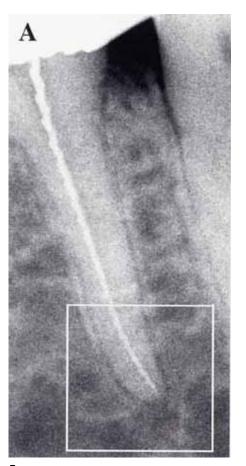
Image resolution is important for viewing fine detail. This is a portion of a conventional radiograph. The apical region (in white box) is shown in Figures 6b-d.
